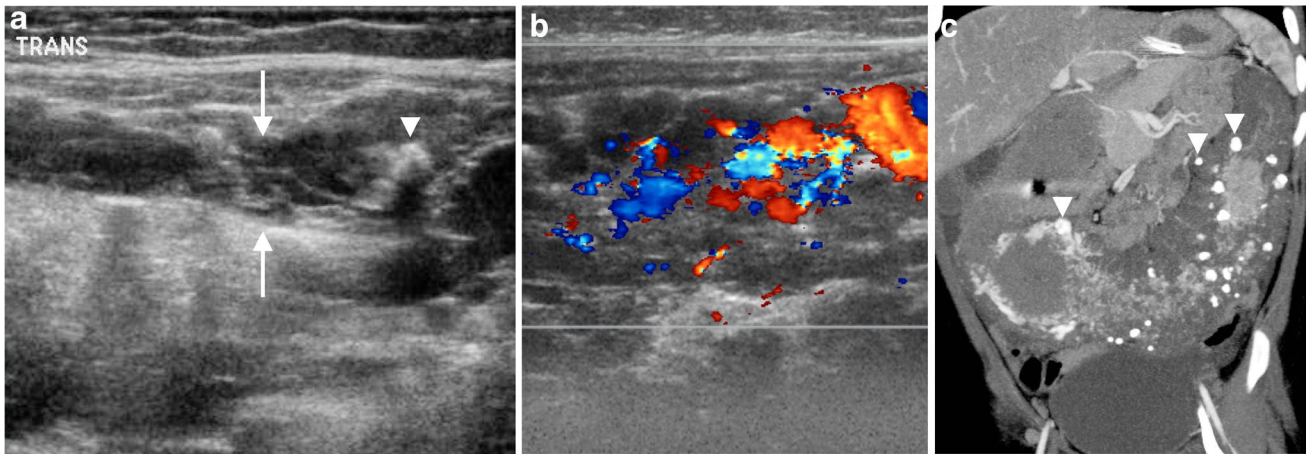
Recurrent intussusceptions and diffuse colonic venous malformation in a 1-year-old girl. a, b Transverse gray-scale (a) and color Doppler (b) US images of the transverse colon demonstrate mural thickening and replacement of the normal mural architecture by numerous lobular hypoechoic spaces (*arrows*), irregular
